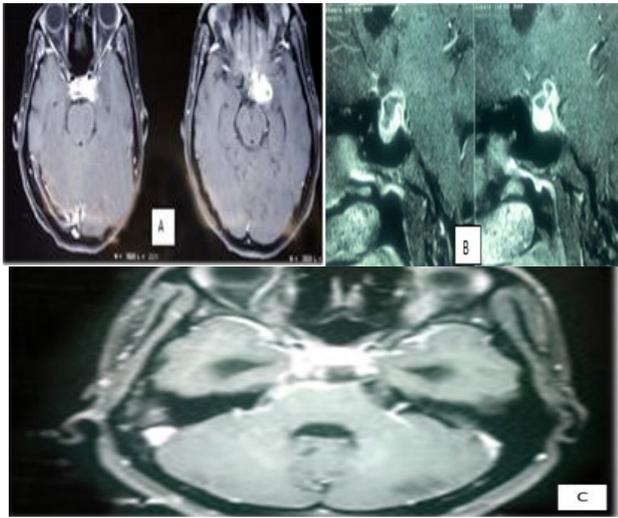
MRI brain of patients. A) Axial section MRI brain T1 contrast study showing a conglomerated heterogenous rim, nodular enhancing lesion in the left parasellar region with dense enhancing basal exudates encasing the ipsilateral internal carotid artery. B) Sagittal section MRI brain T1 contrast study showing ring enhancing lesion involving optic chiasma with enhancement of supra cellular structure. C) Axial section of MRI brain T1 Contrast study showing exudates across base of brain, optico chiasmatic arachnoiditis along with dialation of temporal horn of lateral ventricles and fourth ventricle.
